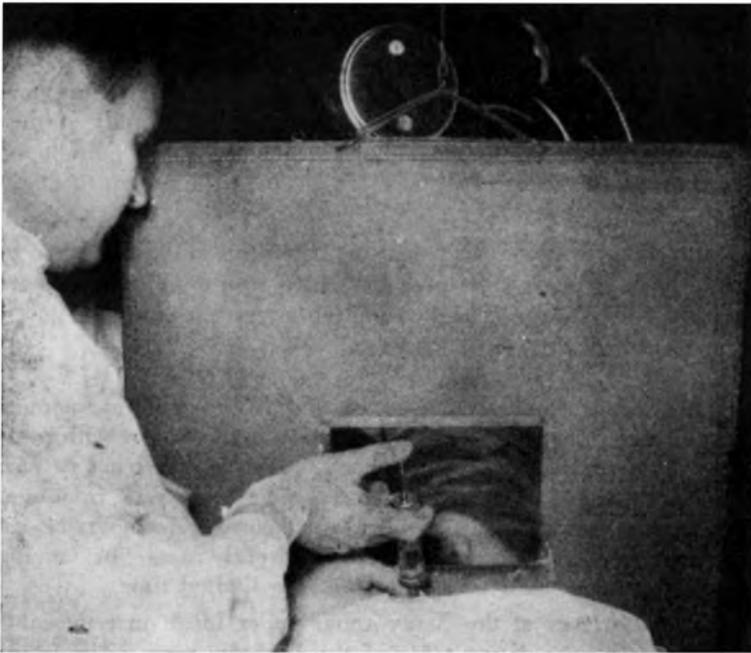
The lead shield protecting the doctors from the exposure to the x-rays. The shield is lowered into position immediately before the exposure. A semicircular piece has been cut in the shield fitting the neck of the patients.
